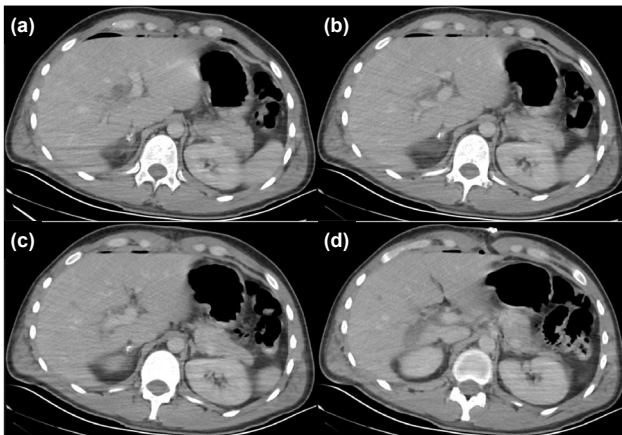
(a,b,c,d) Computed tomography (CT) performed on postoperative day 3 for evaluation of jaundice and melena. No obvious vascular injury was observed.
